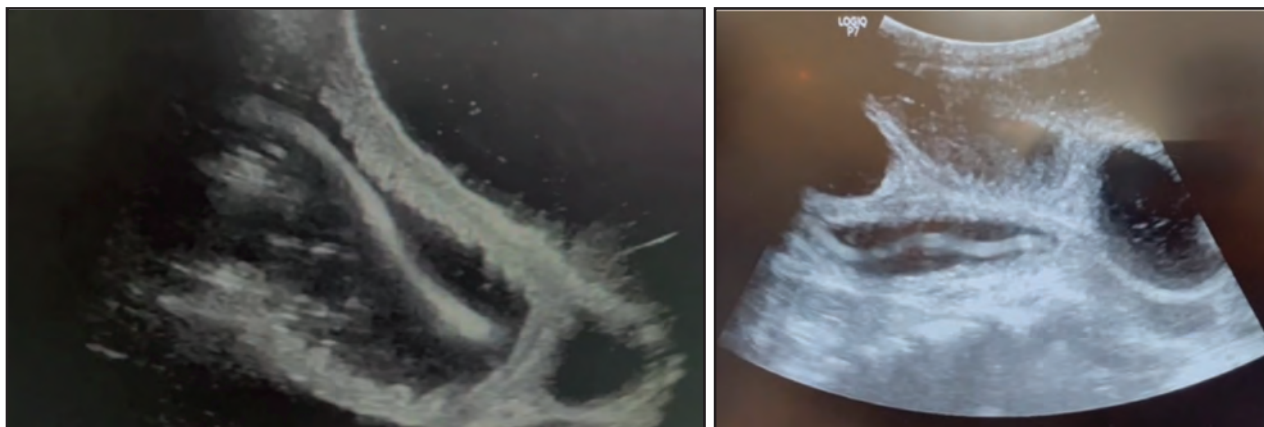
Several mobile hypoechoic tubular structures with well-defined echogenic walls were seen within the intestines on abdominal ultrasonography. In real-time, the 'structures' were freely moving
